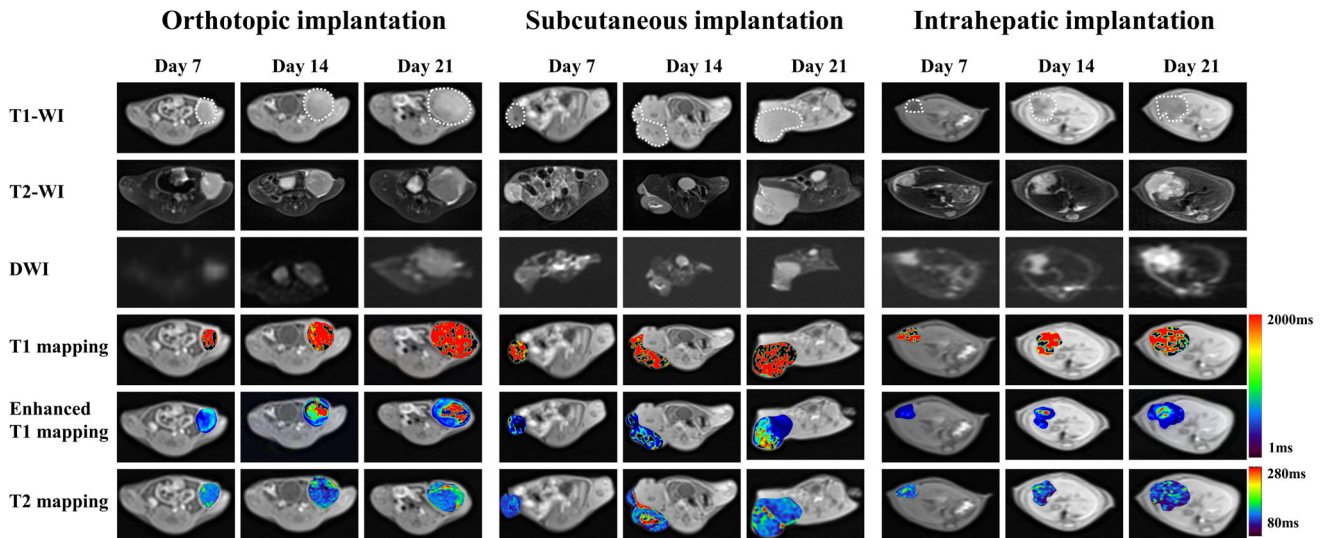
Example T1-weighted, T2-weighted, diffusion-weighted imaging (DWI), T1 mapping, enhanced T1 mapping, and T2 mapping images acquired at 7, 14, and 21 days after implantation. (a) Orthotopic implantation; (b) heterotopic subcutaneous implantation; (c) Heterotopic intrahepatic implantation. Example tumors represented as round or oval shape with mixed hyperintense T2-WI signal and hypointense T1-WI signal.
